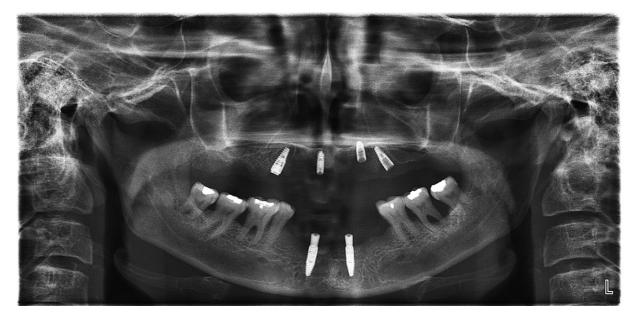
Radiograph of implant placements.
